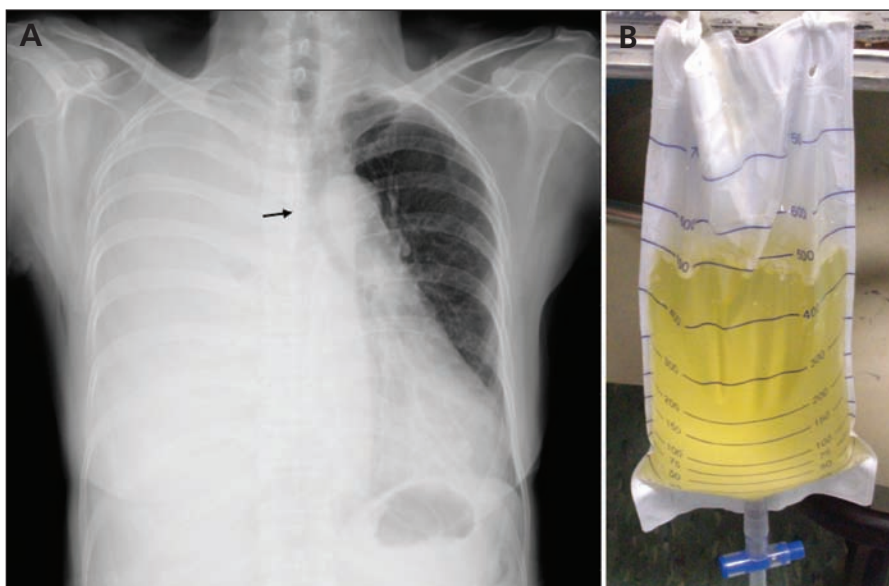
(A) Chest radiograph showing a large pleural effusion with a mediastinal shift to the left (arrow) in a 59-year-old woman receiving continuous ambulatory peritoneal dialysis. (B) The pleural fluid was clear and yellowish, similar to the peritoneal dialysate.
